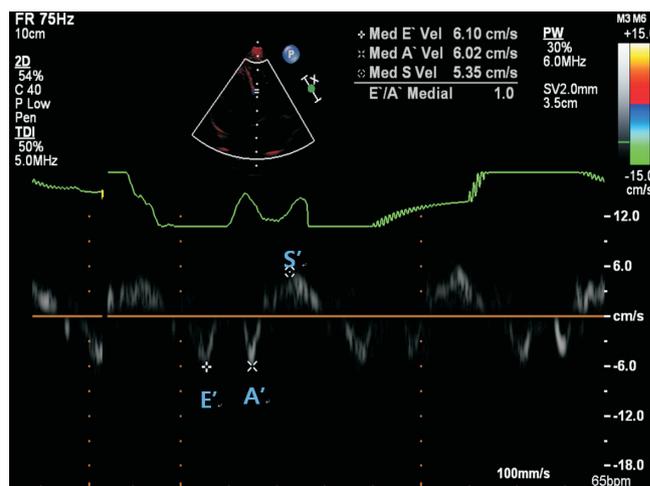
Myocardial velocity by tissue Doppler imaging in Kawasaki disease patient. E', early diastolic myocardial velocity; A', late diastolic myocardial velocity; S', systolic myocardial velocity.
